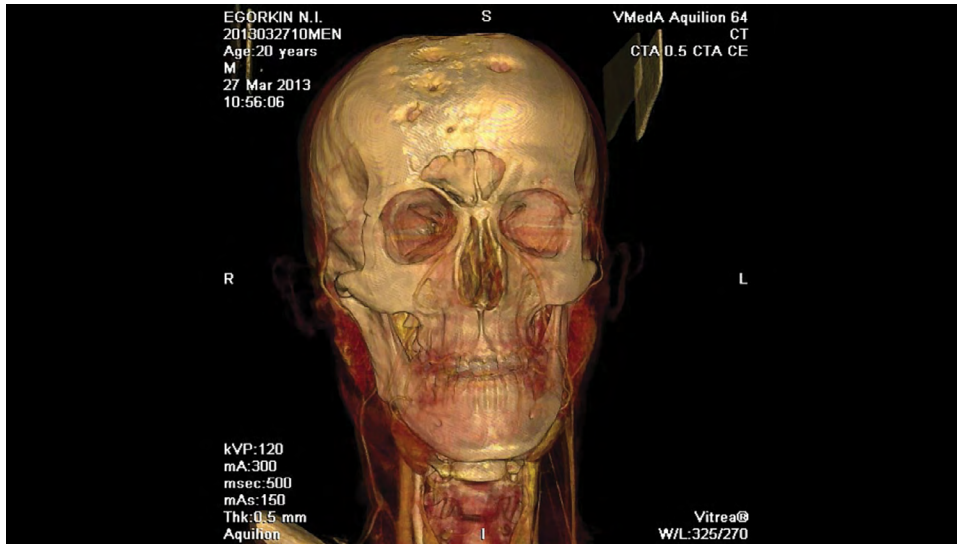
Computed tomography (CT) of the facial skull bones before the facial allotransplantation surgery.
